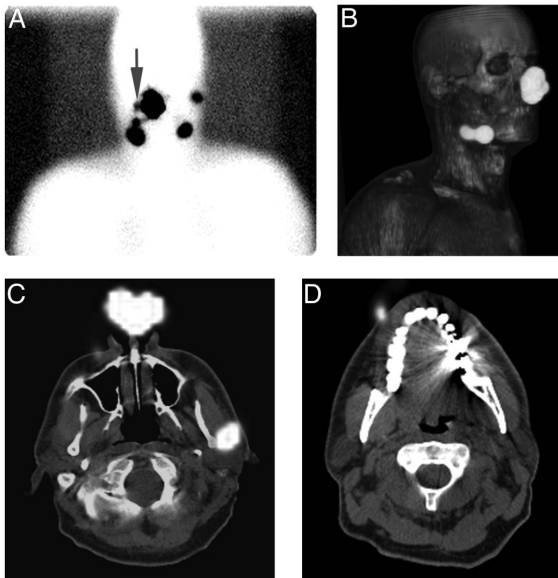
A 46-year old man with a melanoma on the tip of the nose. Conventional images after two hours (A) show bilateral drainage. Two hot spots in the left neck were regarded as sentinel node, and three hot spots in the right neck were classified as sentinel node (blue arrow and two caudal hot spots). This three-dimensional reconstruction of the single photon emission computed tomography with computed tomography (SPECT/CT; B) shows an overview of the radioactivity on the right side only. Two-dimensional SPECT/CT fusion images (C, D) show that the cranial hot spots on the right side are caused by skin contamination. The caudal and most intense hot spot on anterior conventional images (A) appears to be based on two submandibular sentinel nodes (B).
